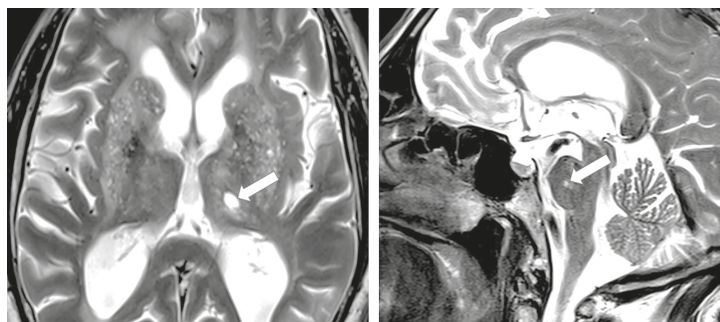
Lacunar postischemic cyst, filled by liquor in the area of left thalamus (T2-weighted image, axial projection) and in the area of pons varolii (T2-weighted image, sagittal projection)
